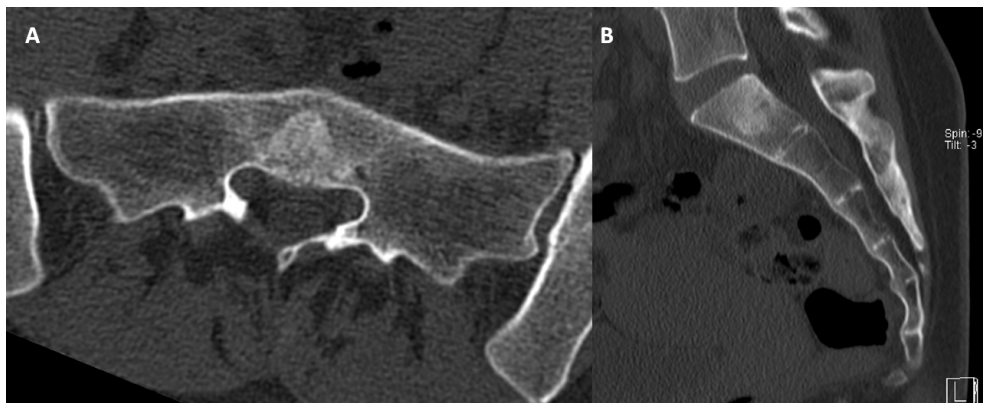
Axial (A) and Sagittal (B) CT images of the lumbosacral spine show a mild osteosclerotic lesion in the midline of the S1 vertebral body, with poorly defined margins and preservation of the trabecular bone pattern. No evidence of bone destruction or soft tissue involvement is observed.
